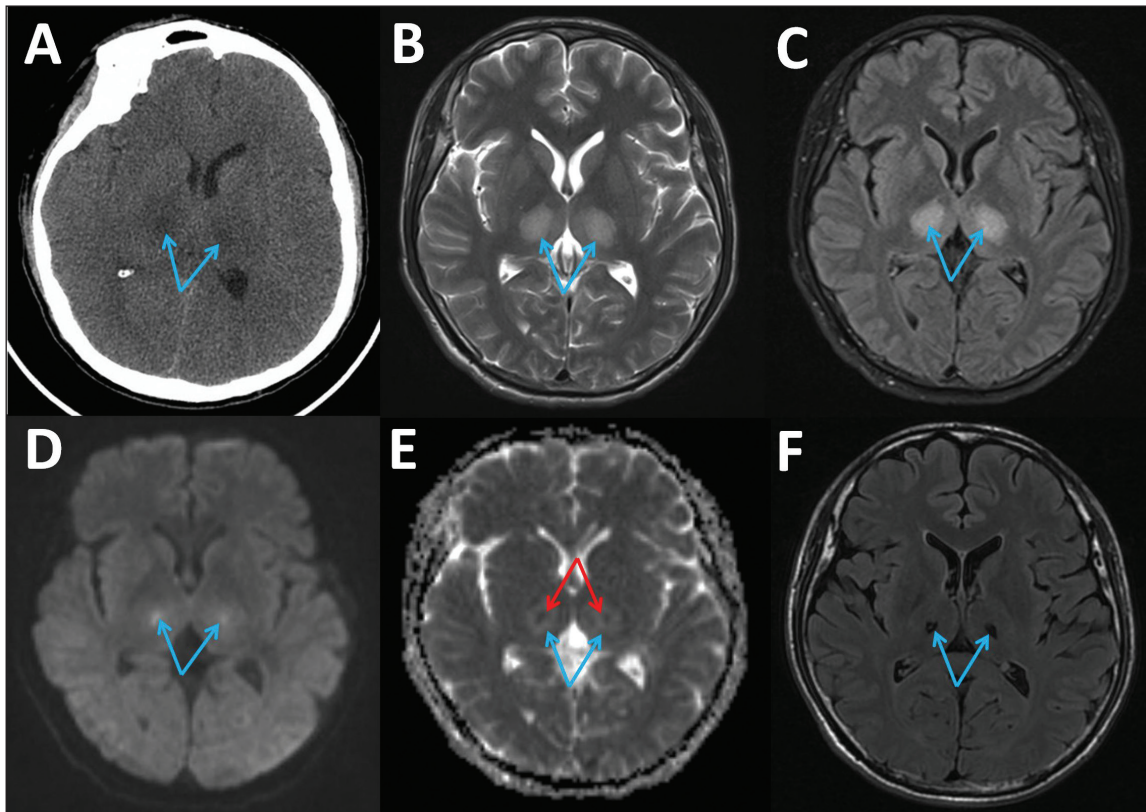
(A) CT and (B–E) MRI (B, T2WI; C, FLAIR; D, DWI; E, ADC) showed symmetric lesions on the bilateral thalamus. (D) DWI revealed high signal intensity (blue arrow). (E) ADC revealed symmetrical concentric thalamic lesions: reduced signal intensity in the core (red arrow), corresponding to diffusion restriction; and increased signal in the outer layer (blue arrow), corresponding to vasogenic edema and diffusion enhancement. (E) Follow-up MRI-FLAIR showed low signal intensity in the core of the lesion (blue arrow), indicative of (F) iron deposition.
